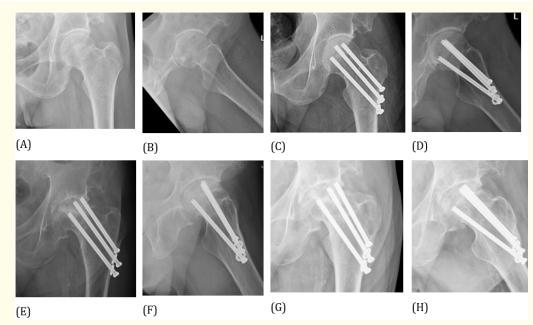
Radiograph of patient with post-operative AVN of femoral head. Pre op (A and B), immediate post-operative (C and D), partial collapse with early hip osteoarthritis at 1 year (E and F), 2-year post op with AVN and advanced OA (G and H).
